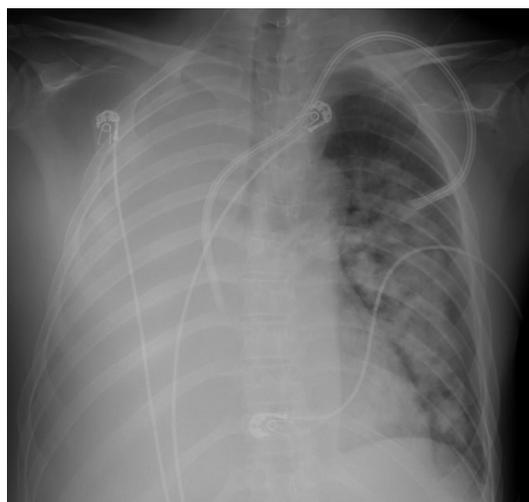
CXR showed complete opacification of the right hemithorax and extensive left lung opacities. CXR, chest X-ray.
